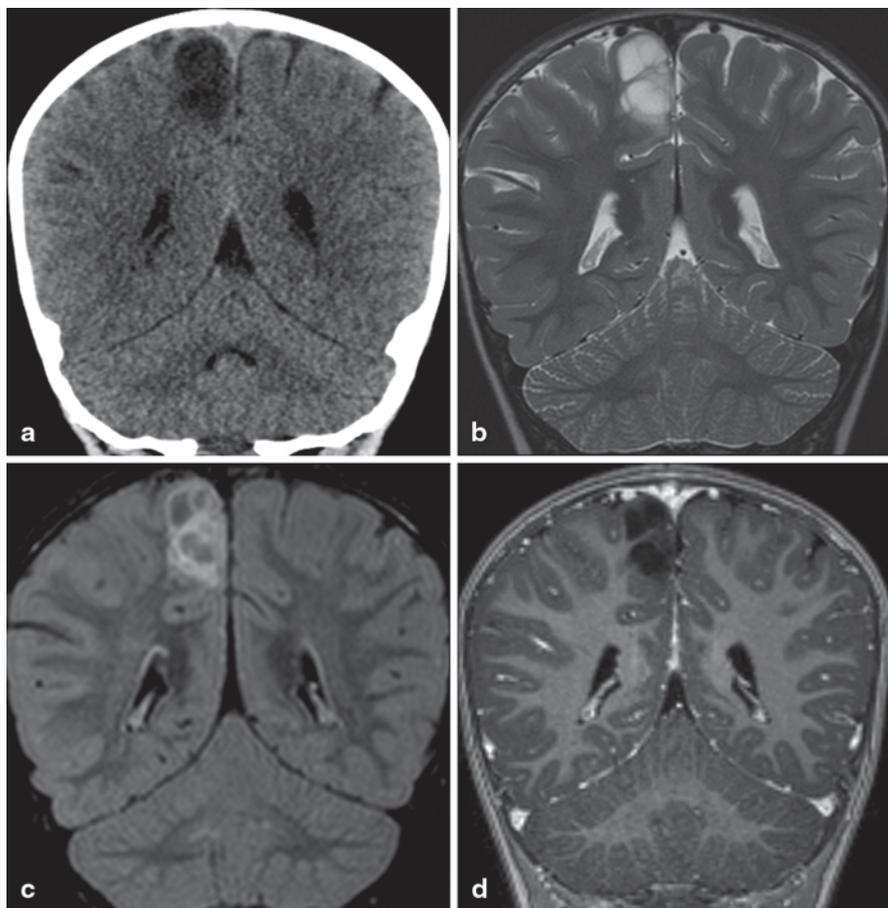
DNT in a 6-year-old boy. a Coronal CT scan. b Coronal FLAIR image. c Coronal FLAIR image. d Coronal Gd-enhanced T1-weighted image. Right paracentral lobule, cortical-subcortical, lesion whose density (a) and signal intensity on T2 (b) is cystlike. Corresponding FLAIR image (c) shows bright internal septa and lesion periphery producing a multicystic “bubbly” appearance. Following gadolinium administration enhancement is absent (d)
